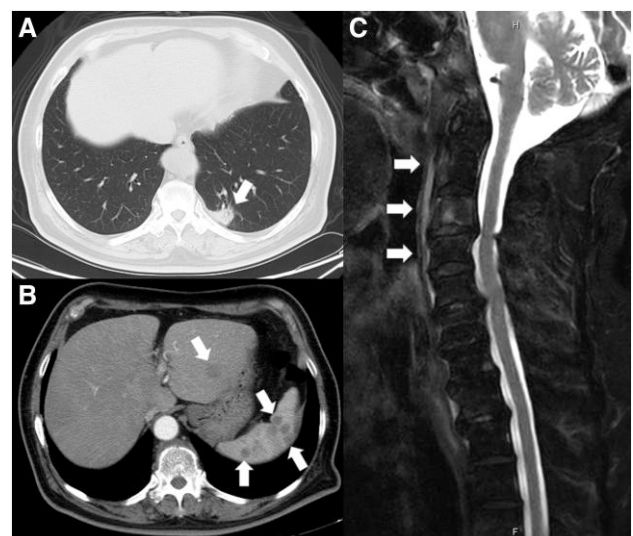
Image findings of interferon- γ neutralizing autoantibodies-related disseminated *Mycobacterium colombiense* infection. Contrast-enhanced computed tomography shows alveolar opacity in the left lung (A) and multiple masses in the liver and spleen (B). Magnetic resonance imaging (T2 STIR scan) shows vertebral space infection around the second to fourth cervical spine vertebrae (C).
